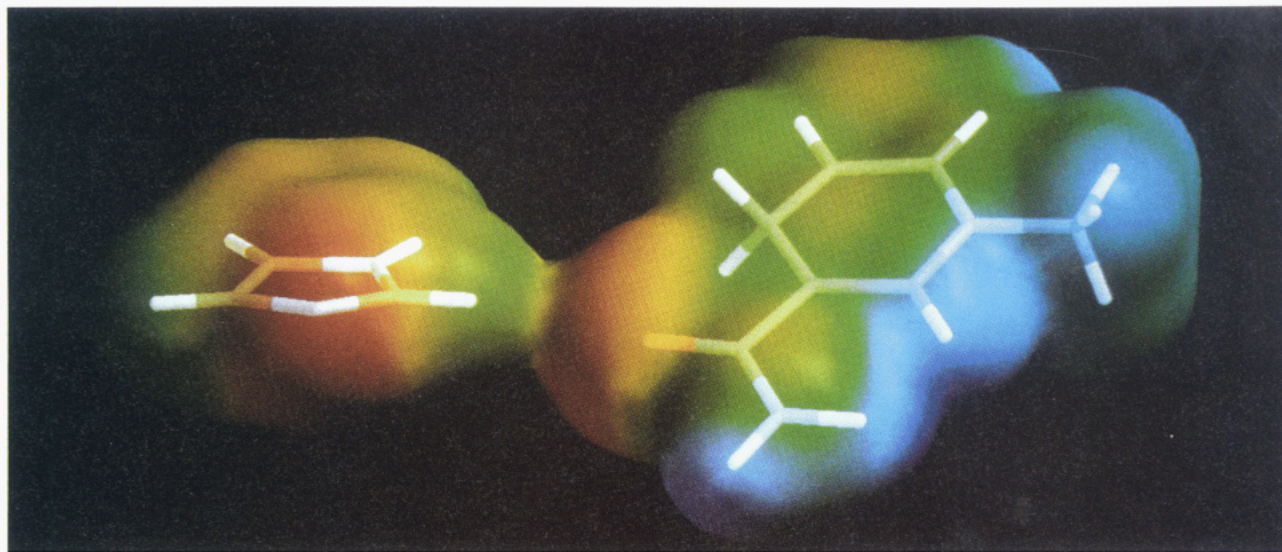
RHF/6-31G* single-point electron density and electrostatic potential shown as a colored surface (as in Figure 6, except as a solid surface rather than a grid) surrounding imidazole and NicH. The heavy atom locations were taken from the X-ray coordinates of the His234 imidazole ring and the NADPH dihydronicotinamide ring. There is electron overlap, with an approximately 2.6 Å distance from the carbonyl oxygen to the imidazole C2-H.
